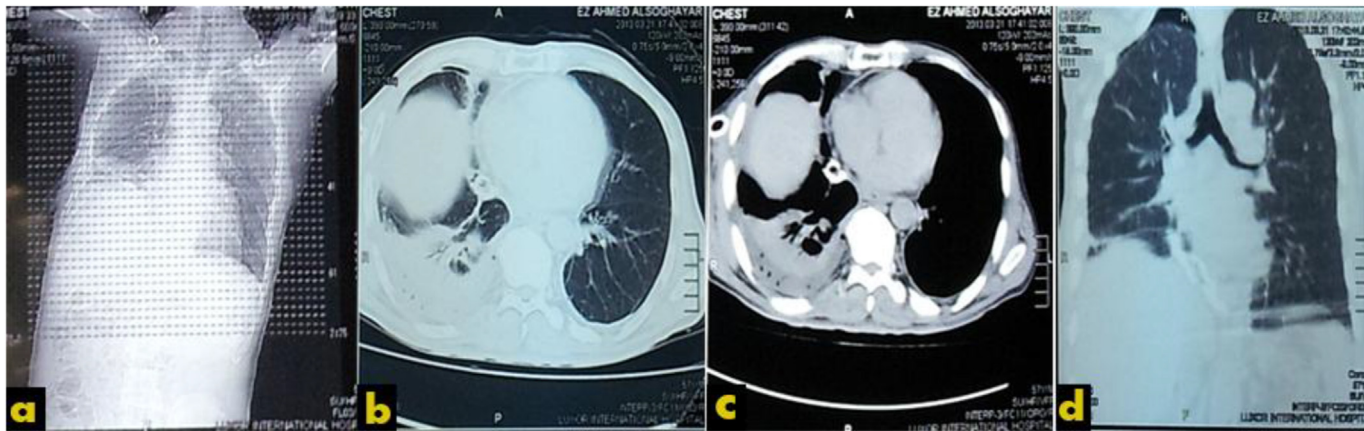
CT Chest of right diaphragmatic hernia. a: Showing right sided multiple fracture ribs, Thoracostomy tube and elevated right copula. B: Showing liver in the right hemithorax. c: Showing lung contusion of right lower lobe. d: Coronal view with rim of pneumothorax.
